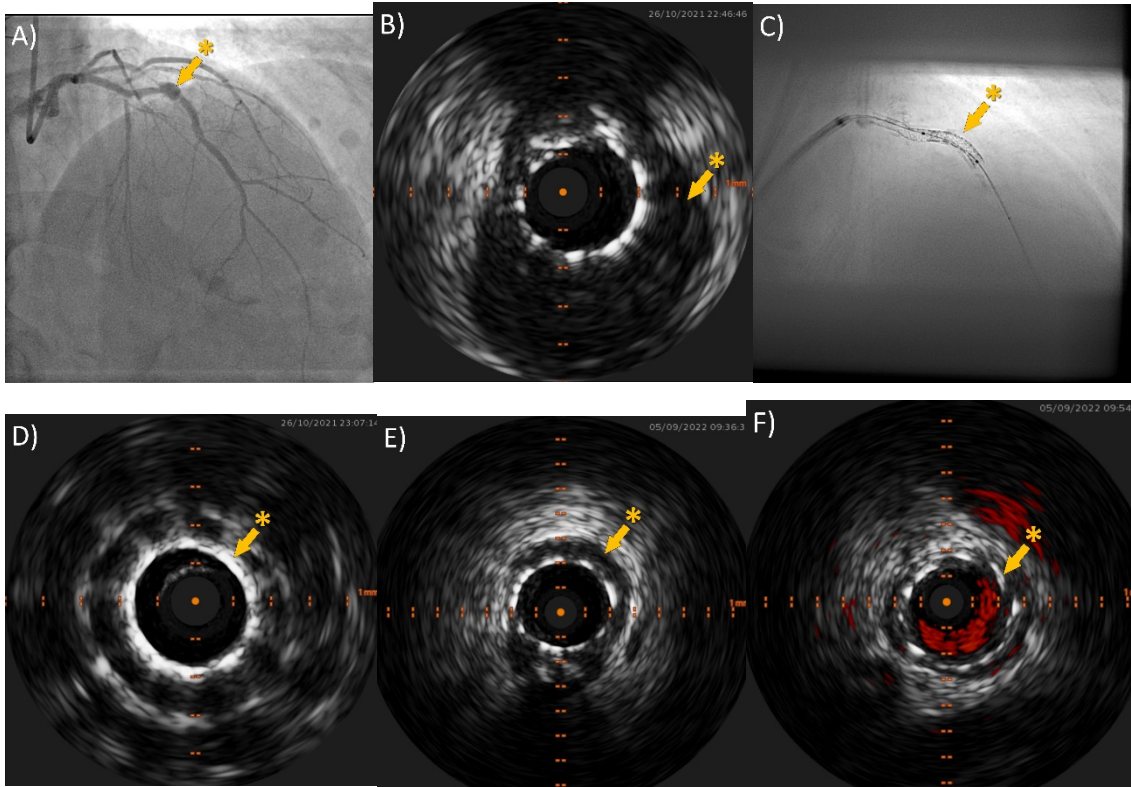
A. Angiography: the image of coronary artery aneurysm (CAA) (*) in medial left anterior descending artery (LAD). B. Intravascular ultrasound IVUS imaging of CAA (*). C. ClearStent view of medial LAD after covered stent placement (*). D. IVUS imaging of covered stent in CAA (*). E. IVUS imaging of covered stent — suboptimal stent expansion (*). F. IVUS imaging of covered stent after optimization (*)
